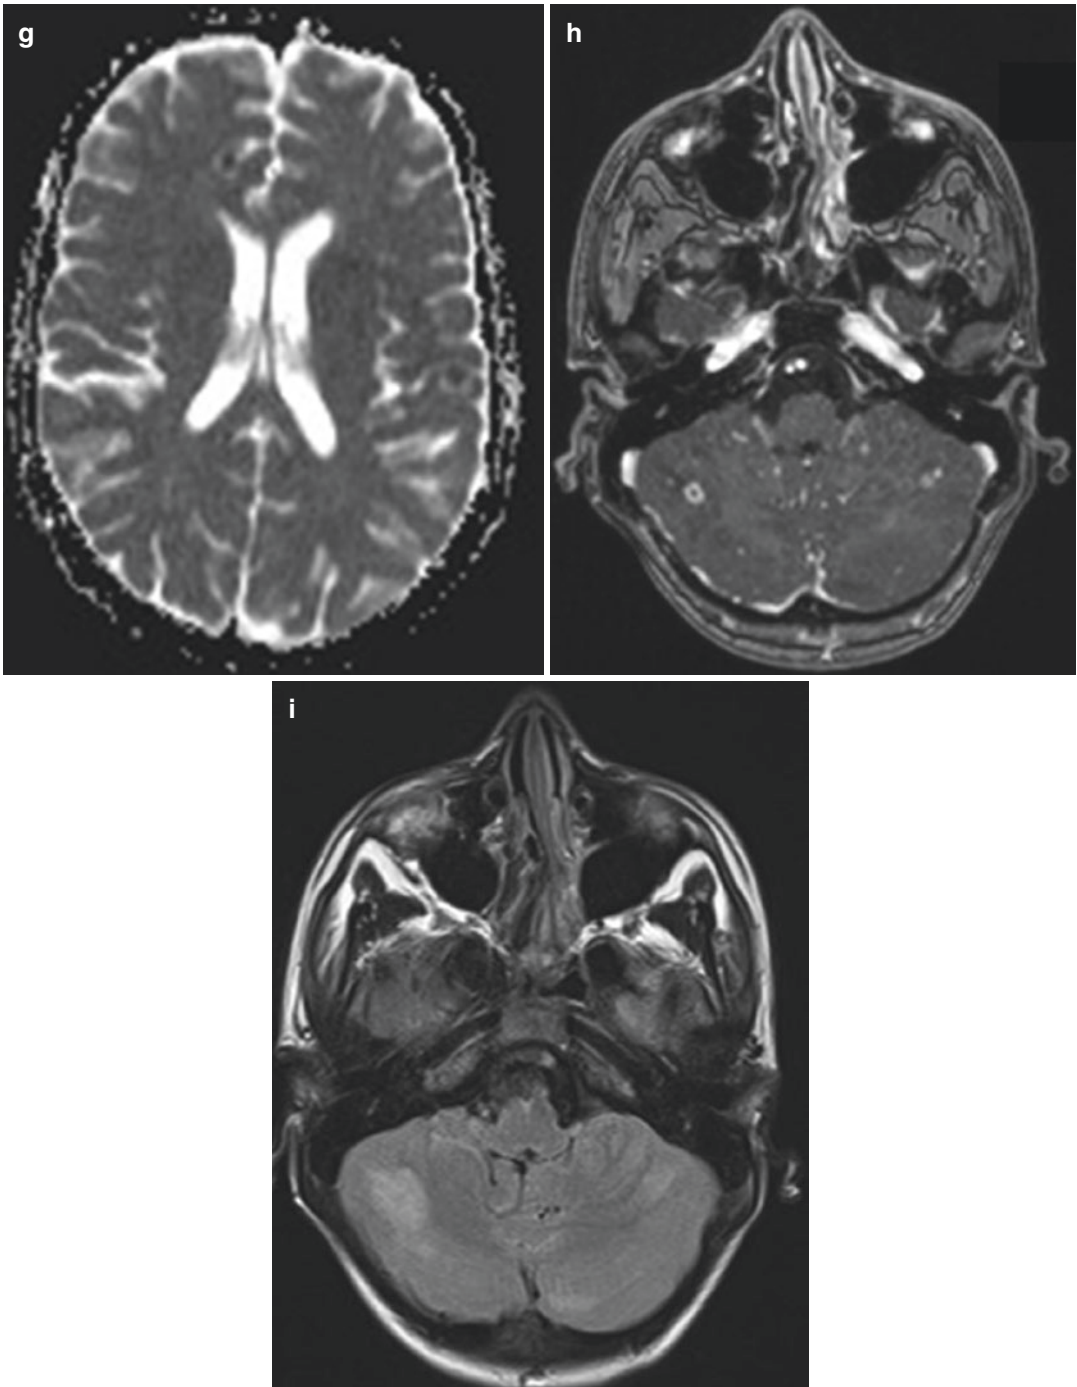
Cerebral aspergillosis in a 15-year-old boy with AML and chloroma; neutropenic fever since 2 weeks and recent signs of meningitis, change in behavior, and diplopia. Axial CT images (a, b) show hypodense cerebral lesions
